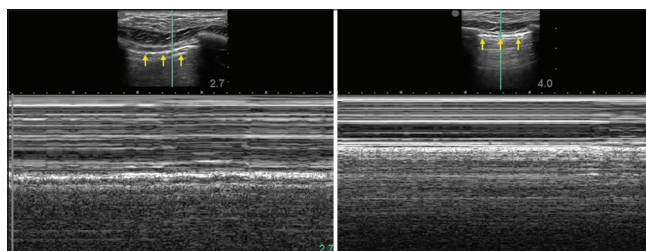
Left: Ultrasound examination showing the absence of pleural sliding (arrow) verified with no motion identified with M-mode. Right: Normal pleural sliding (arrow) restored after repositioning of tracheal tube
